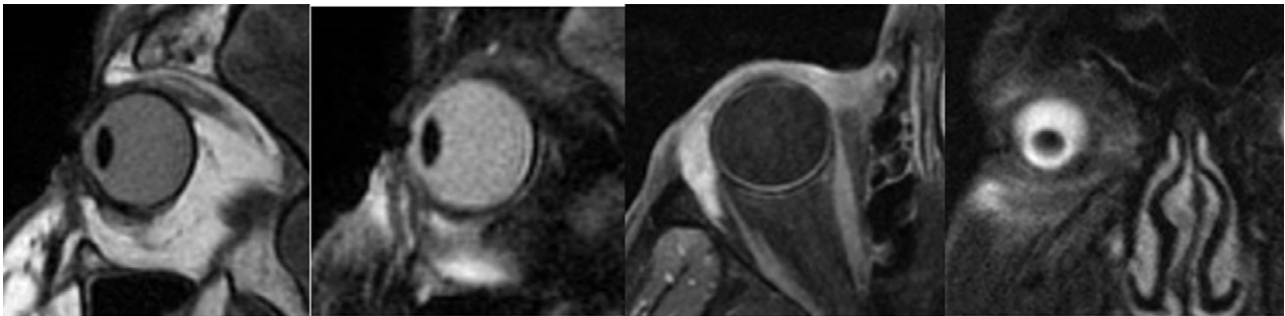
MRI images show the complete resolution of the disease.
